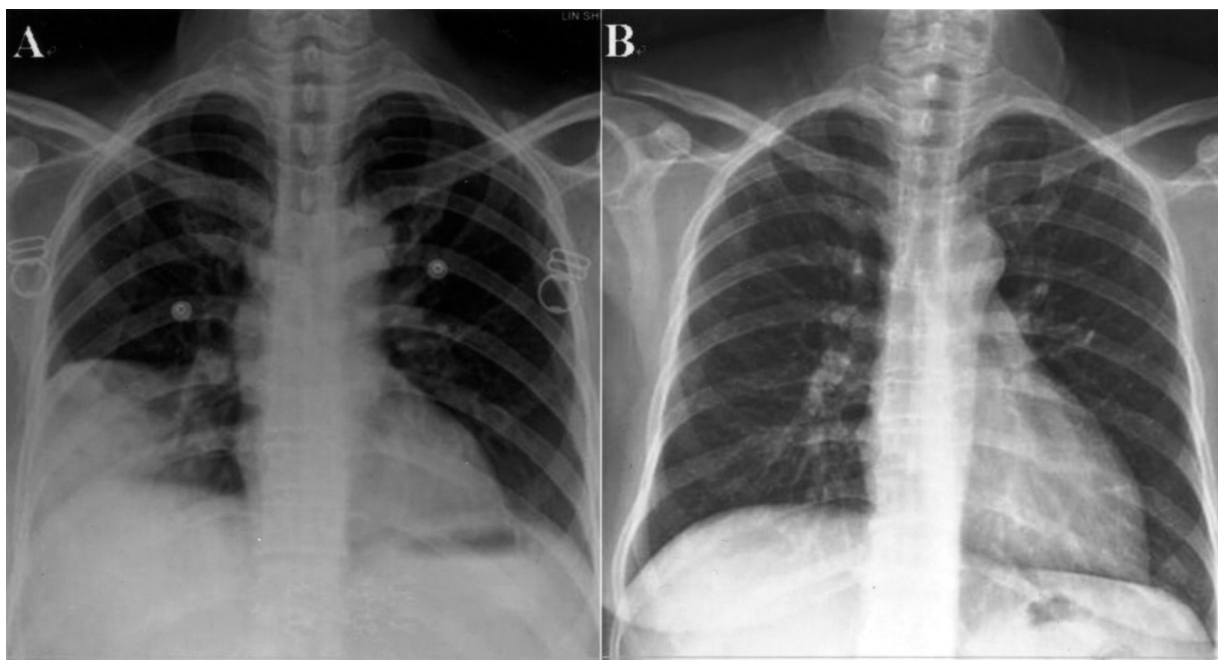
Serial chest X-rays before and after antifungal therapy: (A) Initial chest X-ray revealed patchy opacity in the lateral aspect of the right lower lung field. (B) A subsequent chest X-ray 108 days later showed complete resolution of the consolidation after effective antifungal therapy.
